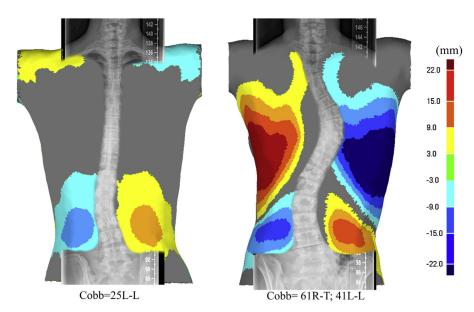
Isolated color patch of two torsos with the corresponding radiograph. The Cobb angles were measured from the corresponding radiograph. L-L, Left Lumbar; R-T, Right Thoracic.
